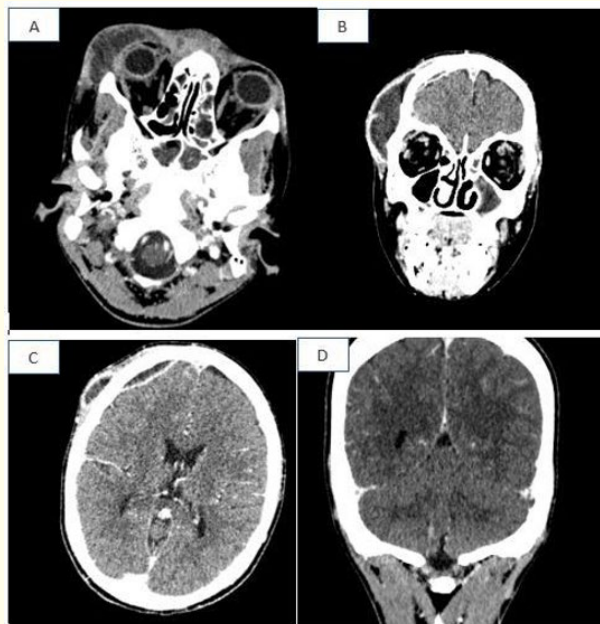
A) Contrast-enhanced CT through the orbits demonstrates frontal sinusitis as well as left pre-orbital cellulitis. B, C) Coronal and axial reconstructed image from CECT shows epidural abscess and subgaleal frontal abscess, D) Bilateral thrombosis of transverse sinuses.
